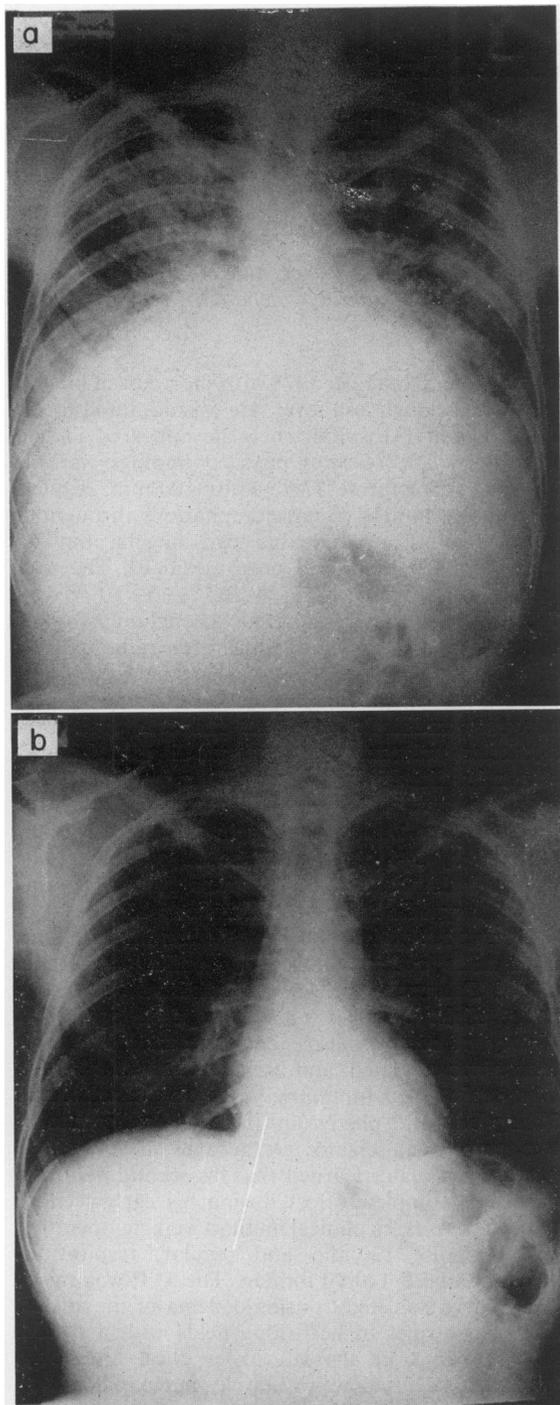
Chest X-rays (a) December 1974. Acute pulmonary oedema during hypocalcaemia. (b) June 1975. Several months after plasma calcium restored to normal. No digoxin or diuretic therapy for 4 months.
